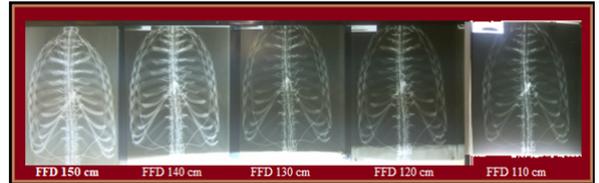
Photographs of the radiographs
